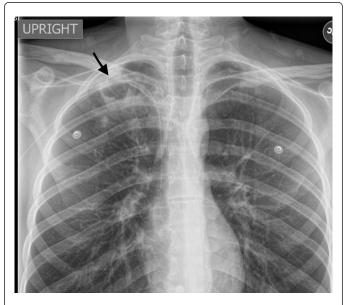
Plain chest x-ray with arrow indicating right upper lobe cavitary opacity.
